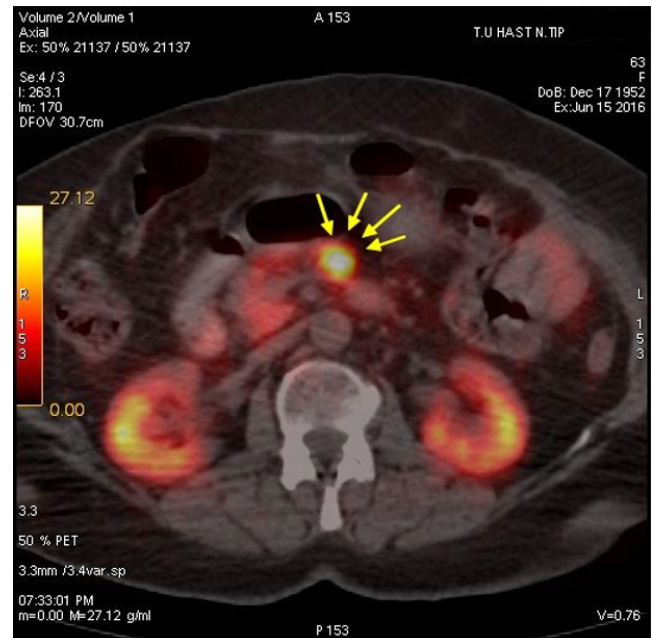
The lesion of pancreas (Transaxial PET CT Fusion)
